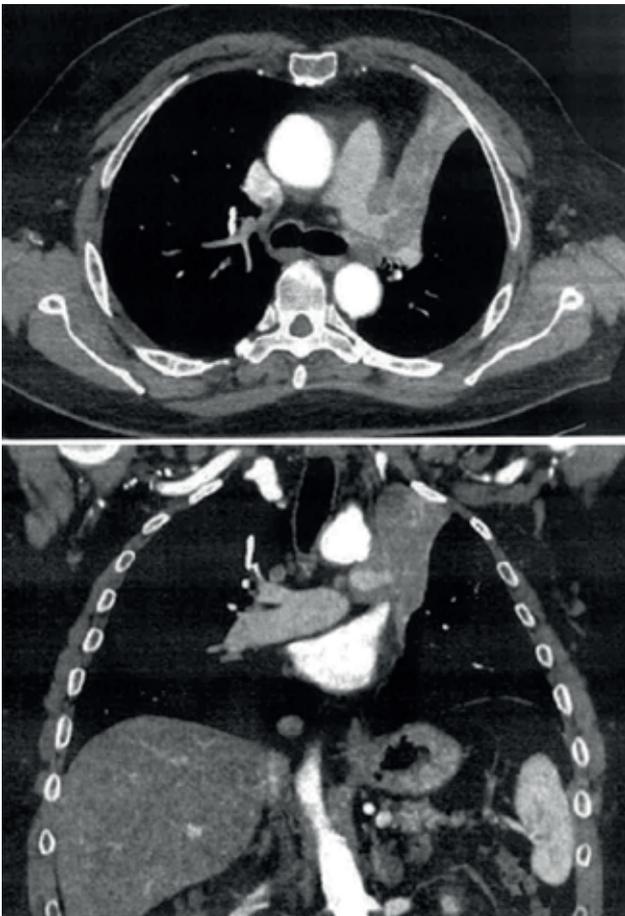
Axial and coronal slices of the preoperative chest CT scan showing the left parahilar mass with complete atelectasis of the left upper lobe. It can be seen how the mass engulfs and narrows the left pulmonary artery with a critical decrease in the caliber of the lobar artery for the LUL and for the LLL.
